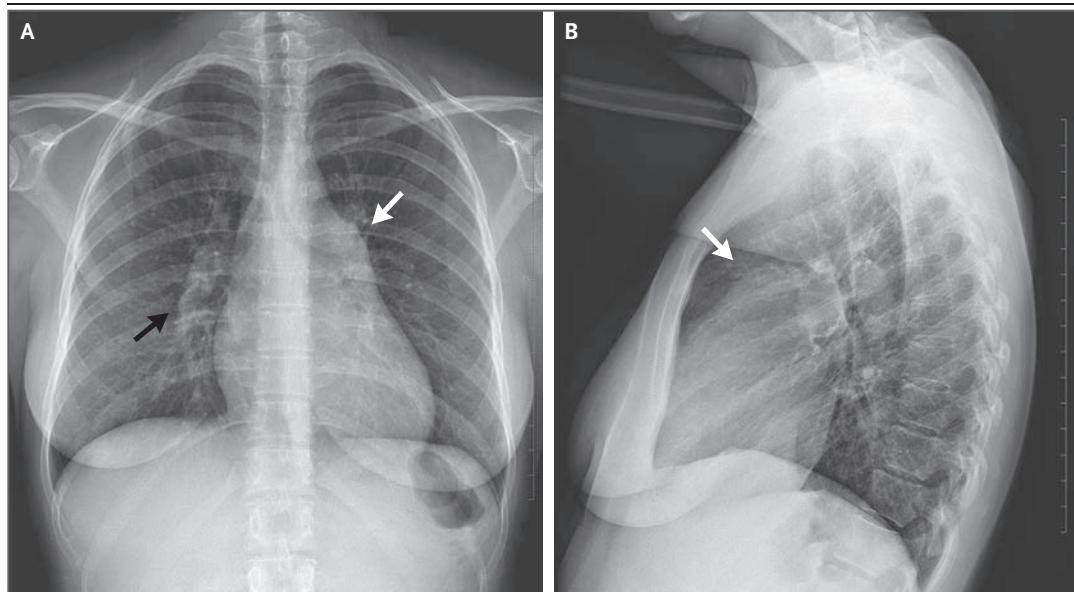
Plain-Film Radiography of the Chest.
